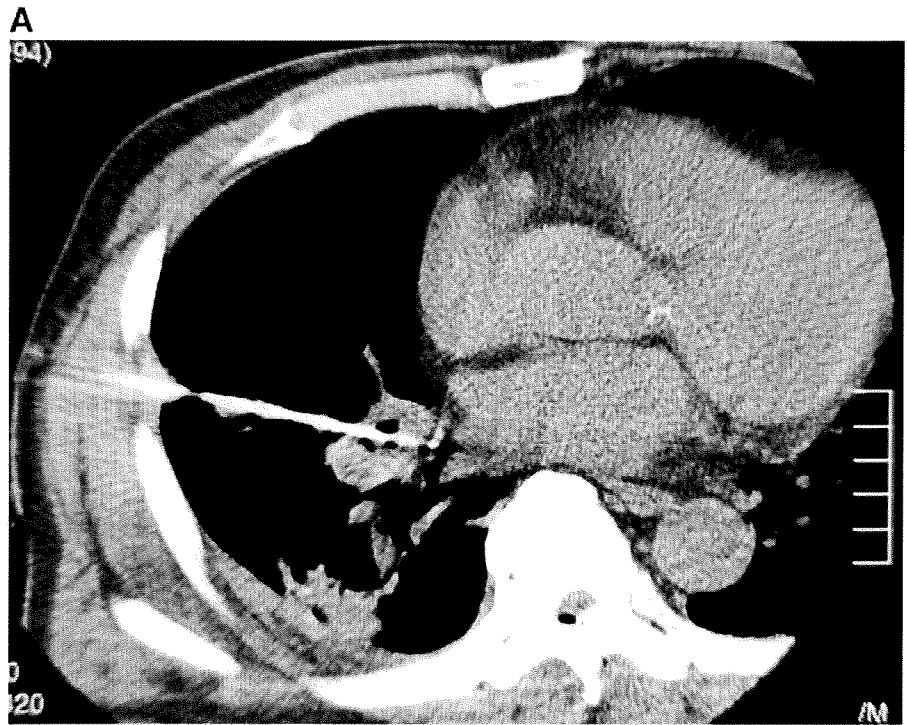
(Top) A 67-year-old man with pulmonary metastases of renal cell carcinoma. Intraprocedural computed tomography (CT) scans demonstrated puncturing of 17-gauge internally cooled electrodes to the right hilar lymph nodes. (Bottom) A 67-year-old man with pulmonary metastases of renal cell carcinoma. Image of the bronchoscopic examination 7 days after radiofrequency ablation (RFA) showed the mucosa of the spur of the right middle lobe and lower lobe bronchus was destroyed.
